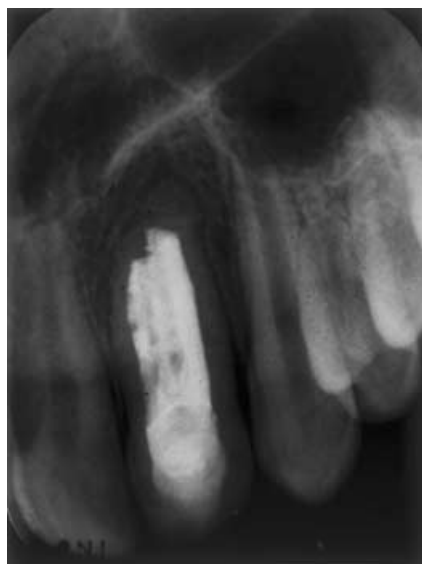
Radiographic follow-up of the invaginated lateral incisor after 1 year shows that apical conditions are normal.
